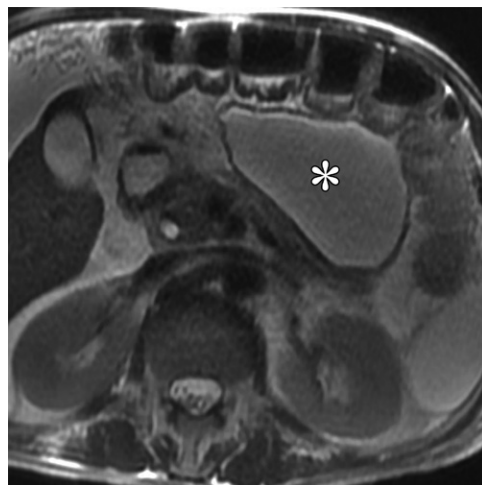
Peripancreatic fluid collection in a 27-year-old man, 5 weeks after the onset of pancreatitis. Axial T2-weighted MR image shows a peripancreatic collection (*), containing homogeneous T2-hyperintense fluid with no debris, consistent with a pseudocyst.
